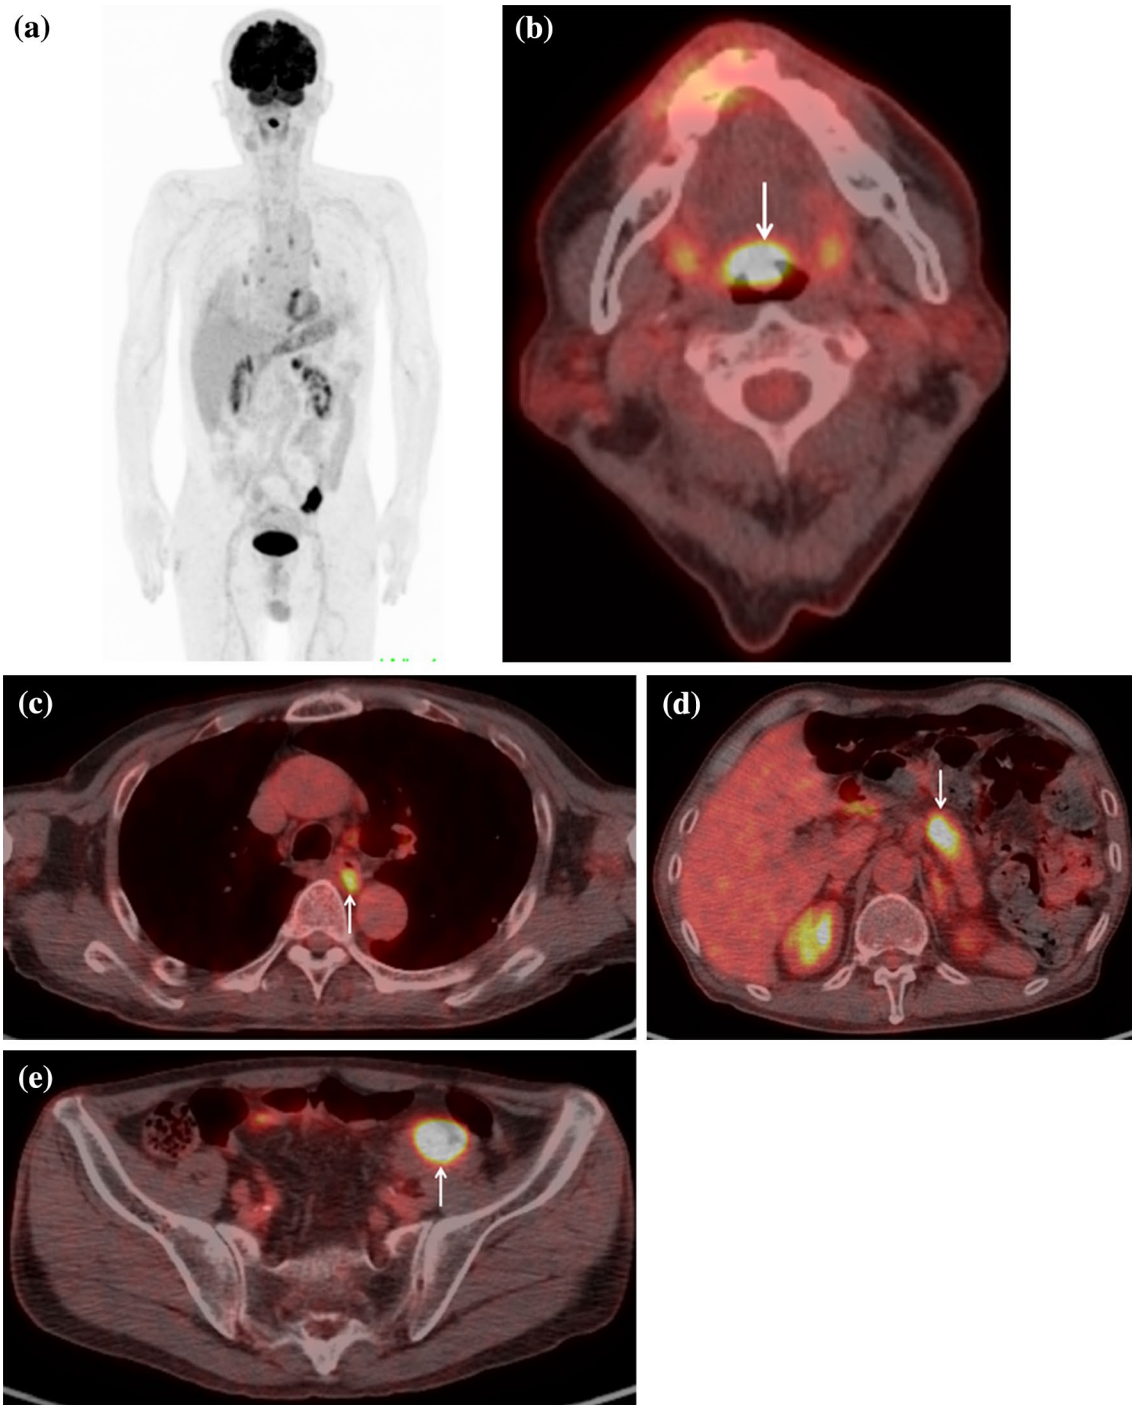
A 71-year-old man with four cancers of the oropharynx, esophagus, pancreas, and sigmoid colon. a Maximum intensity projection (MIP) of FDG-PET shows abnormal FDG uptake in the oropharynx, mediastinum, upper abdomen and pelvis. b FDG-PET/CT shows intense FDG uptake (SUV_{max} : 8.9) corresponding to the uvula (*arrow*), suggesting oropharyngeal cancer. c FDG-PET/CT shows moderate FDG uptake (SUV_{max} : 4.5) corresponding to the esophagus (*arrow*), suggesting esophageal cancer.
